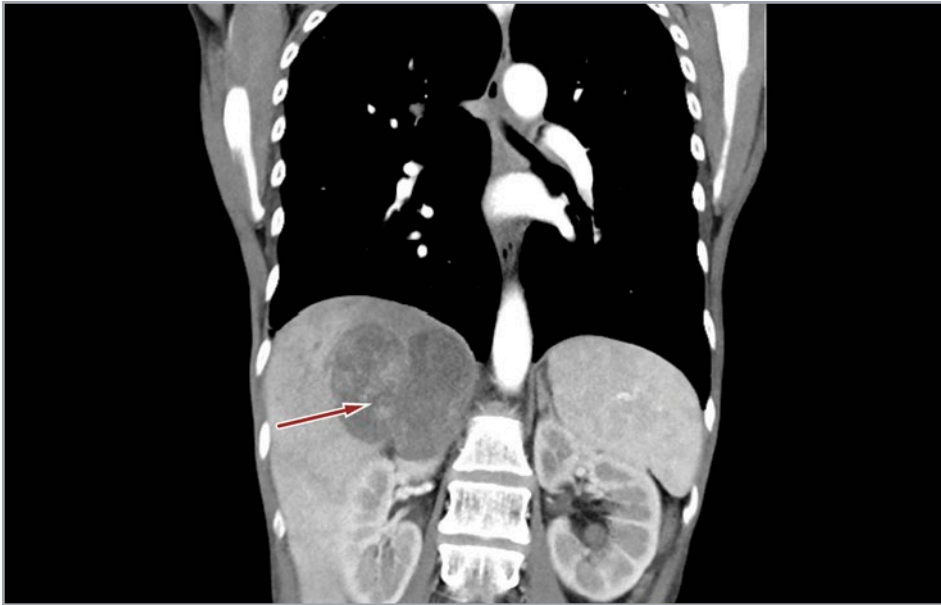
CT scan revealing growing adrenal mass (red arrow) with extensive infiltration of liver and upper pole of kidney (longitudinal plan, ten days after hospital admission)
